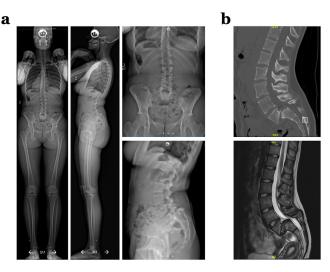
(A) Plain radiographs, anteroposterior (far left and top right) and lateral neutral (middle left and bottom right) views, at preoperative baseline showing Meyerding grade IV L5–S1 spondylolisthesis with chronic bilateral pars interarticularis defects; (B) Computed tomography (top) and magnetic resonance imaging (bottom) showing severe bilateral L5–S1 foraminal stenosis and reactive endplate sclerosis with cystic degenerative change of inferior L5 and superior S1.
